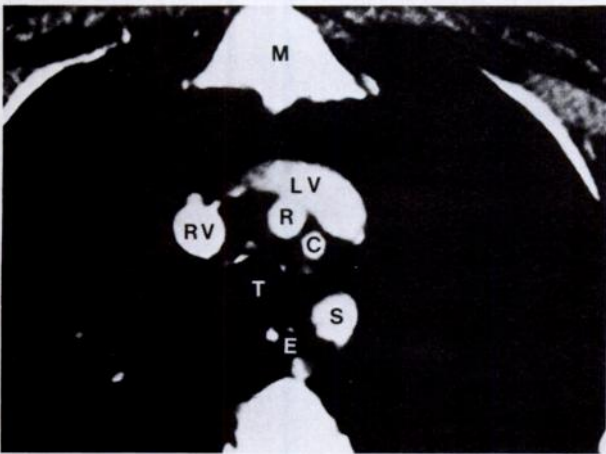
Chest CT scan, case 2, after MV replacement. M=manubrium; LV=left brachiocephalic vein; RV=right brachiocephalic vein; R=right brachiocephalic artery; C=left carotid artery; T=trachea; E=esophagus; S=left subclavian artery.
